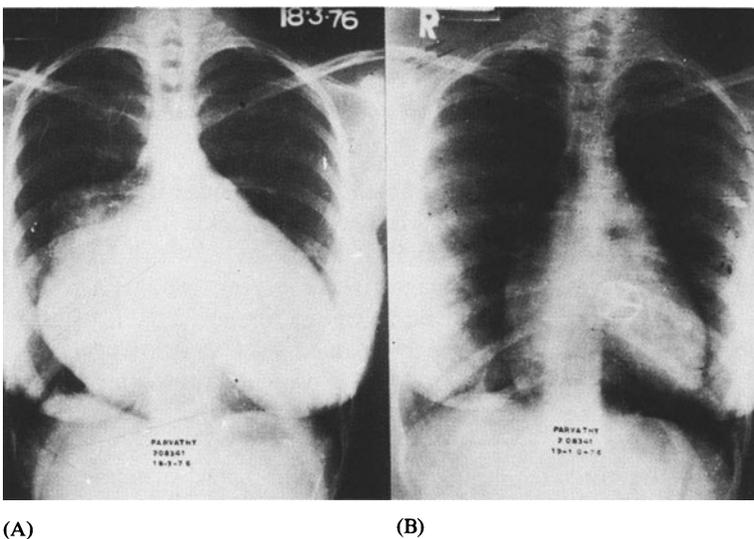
(A) Preoperative X-ray film showing classic features of right ventricular hypertrophy, pulmonary plethora, and right atrial enlargement of Lutembacher's syndrome. (B) Postoperative X-ray film following closure of atrial septal defect and open mitral valvotomy of the same patient.
